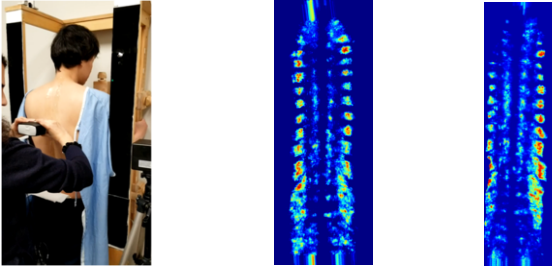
(a) scanning on the volunteer (b) using the new device (c) original Ultrasonix system
